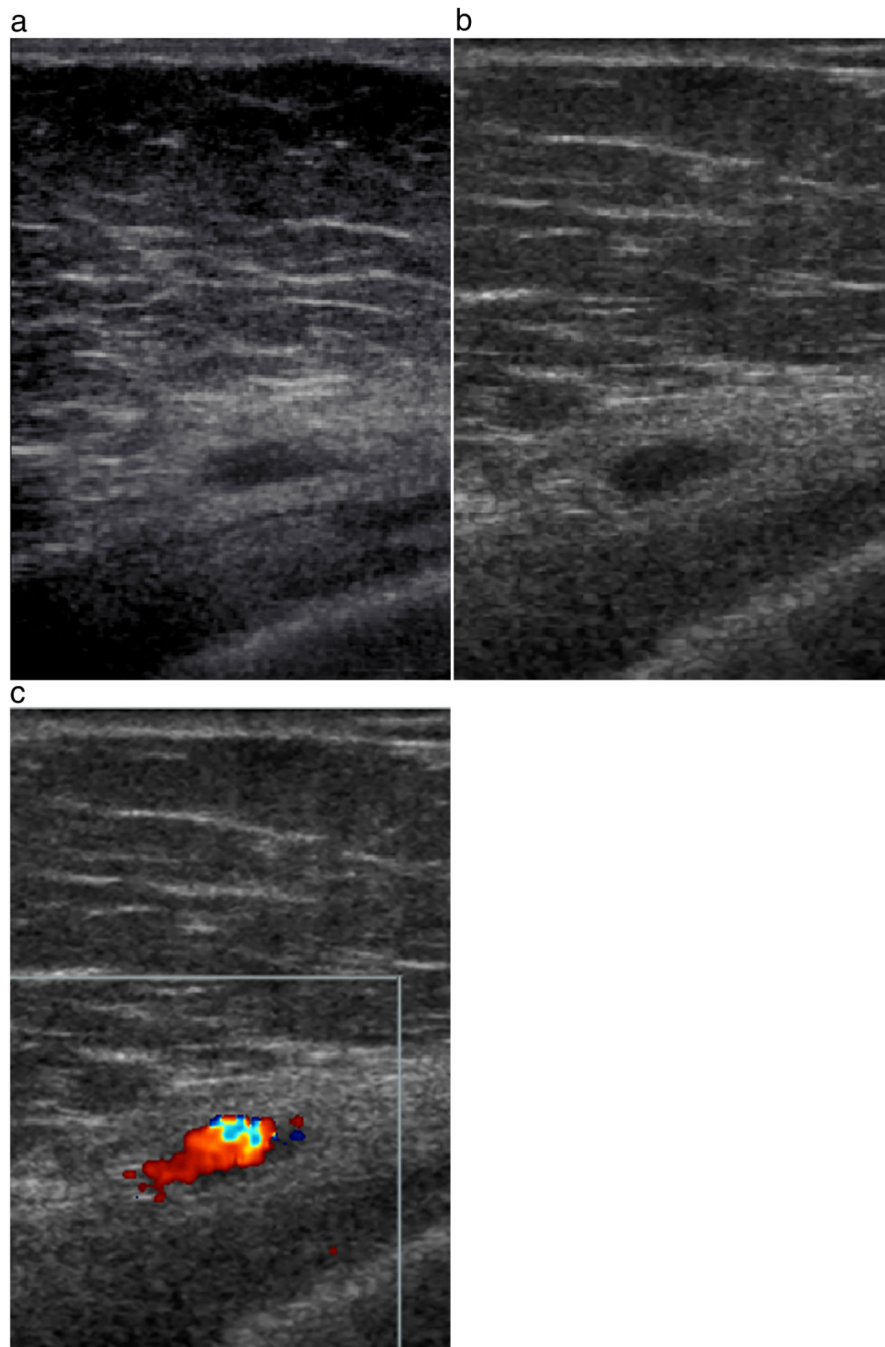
56-year-old woman with a hypoechoic lesion deep in the right breast on the outside screening US study (a) and on RTUR (b). Outside report recommended biopsy of the lesion. On RTUR, color Doppler evaluation (c) demonstrates it was a vessel.
